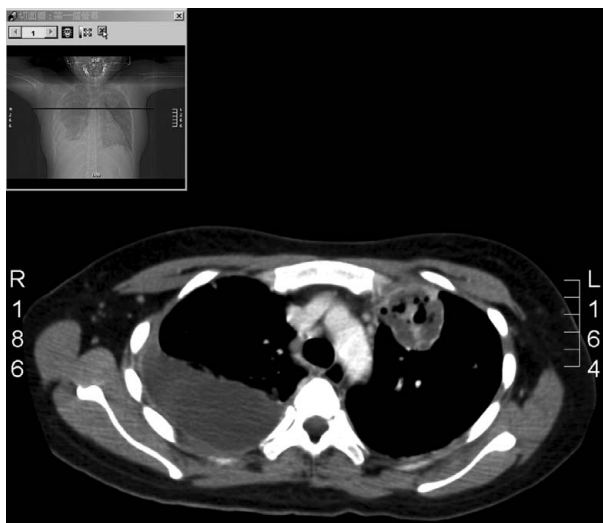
Computed tomography of the chest shows left upper lung cavitary lesion with right pleural effusion.
